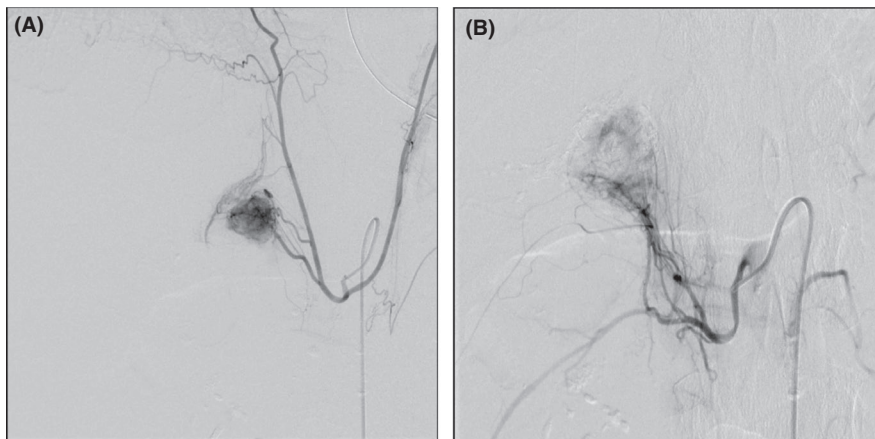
A, Lt. inferior phrenic artery angiography. B, Lt. middle adrenal artery angiography. Two adrenal arteries are embolized with iodized oil injection followed by gelatin sponge. The superior adrenal artery is seen arising from the right inferior phrenic artery (A), and the middle adrenal artery from the aorta (B); they are same as the 3D CT images
